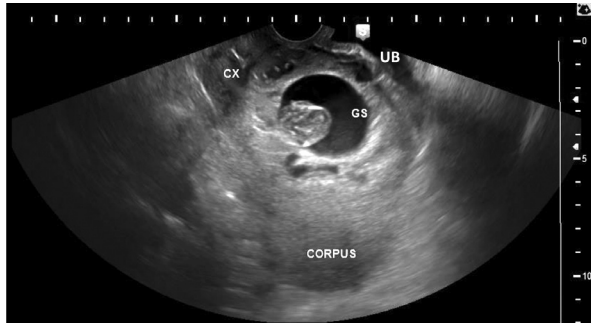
Transabdominal sagittal ultrasound scan showing expansion of the lower uterine segment bulging out to the posterior urinary bladder wall (UB) and the upper third of the cervix (CX); GS (Gestational Sac)
